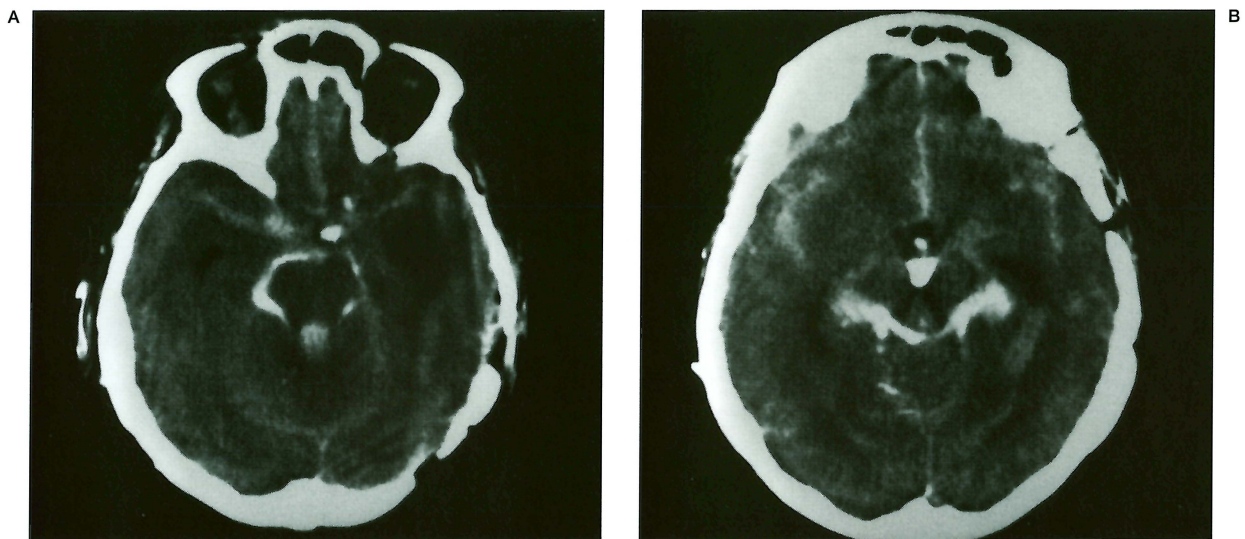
The cranial CT demonstrates the extensive subarachnoid haemorrhage mixed with extravasation of contrast material throughout the basal cisterns (A) and the third ventricle (B).
